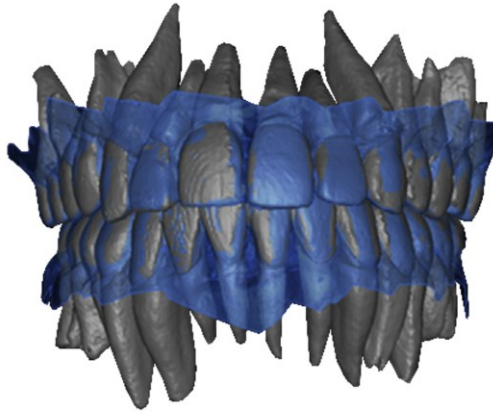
Superimposed segmented teeth from CBCT dataset and scanned teeth by using intraoral scanner (50)
